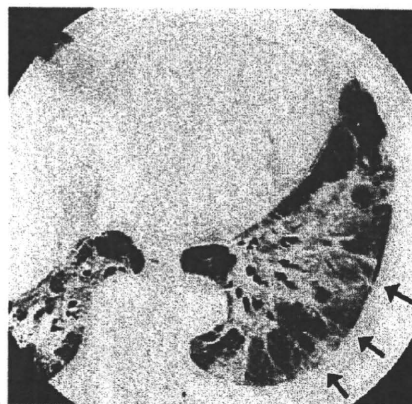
Nonspecific interstitial pneumonia (NSIP) associated with RA in a 55-year-old woman. Transverse thin-section CT (2-mm collimation) through the left lower lobe demonstrates areas of air-space consolidation (arrows) with a predominantly peribronchovascular distribution.
